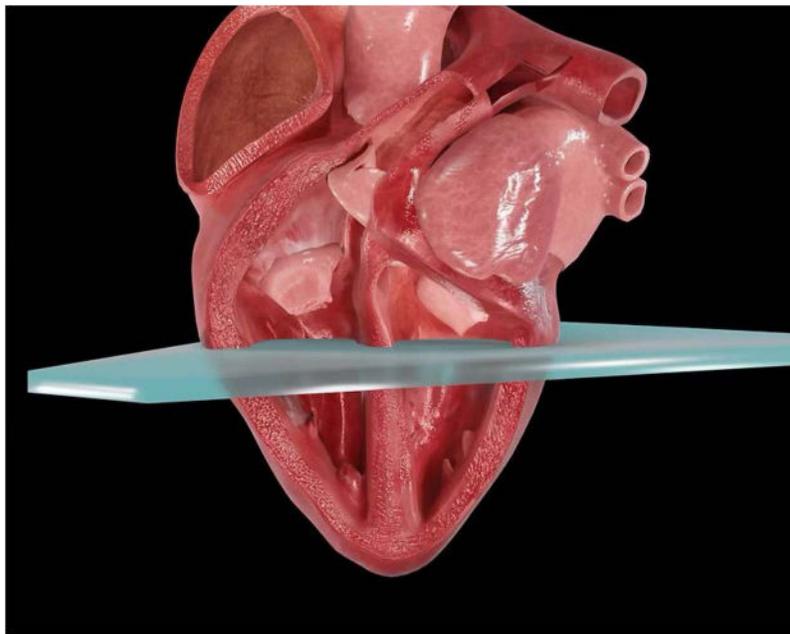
Three-dimensional (3D) animation of heart showing ultrasound (US) plane parasternal short-axis (PSAX).⁴
